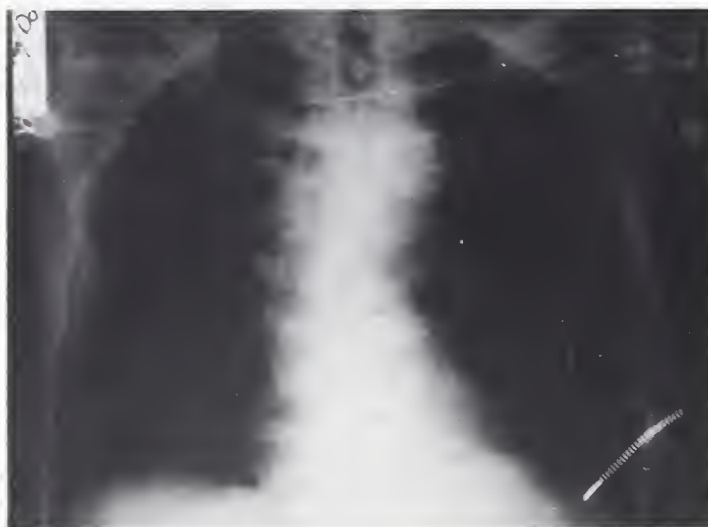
Admission chest x-ray prior to intubation.
